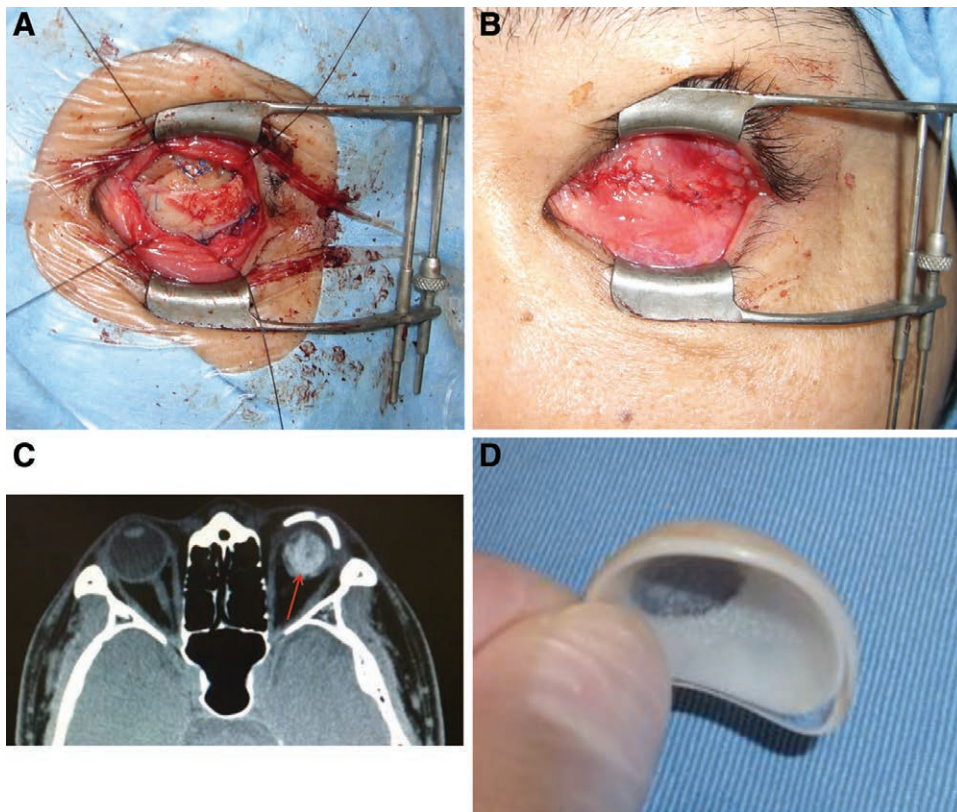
Case 3. A, The spherical costal cartilage implant was inserted into orbit and affixed to 4 sclera flaps. B, Conjunctival sac was sutured. C, Postoperative CT examination showed the spherical costal cartilage implant in his orbit (red arrow). D, The patient was able to wear a thin artificial eye.
